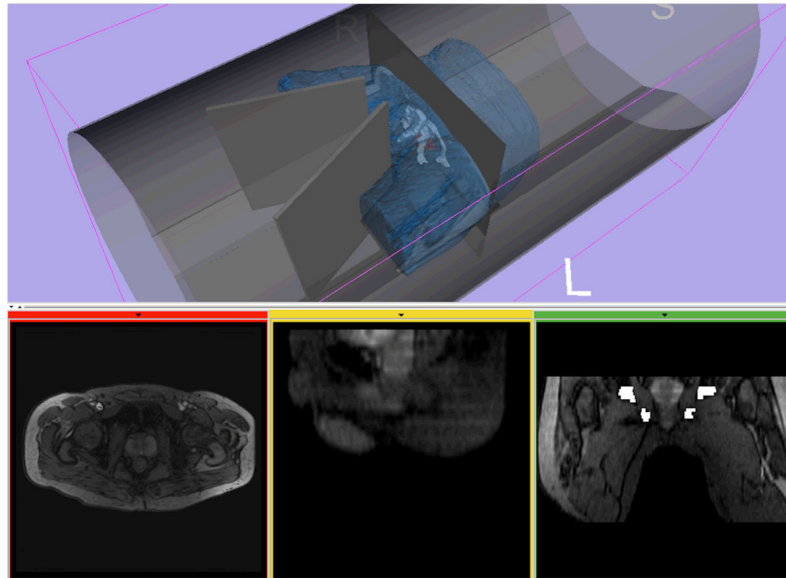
A 3D model of a subject generated from MR images is visualized with models of the bore and the leg splitting tool in medical image processing and visualization software based on 3D Slicer (www.slicer.org)
